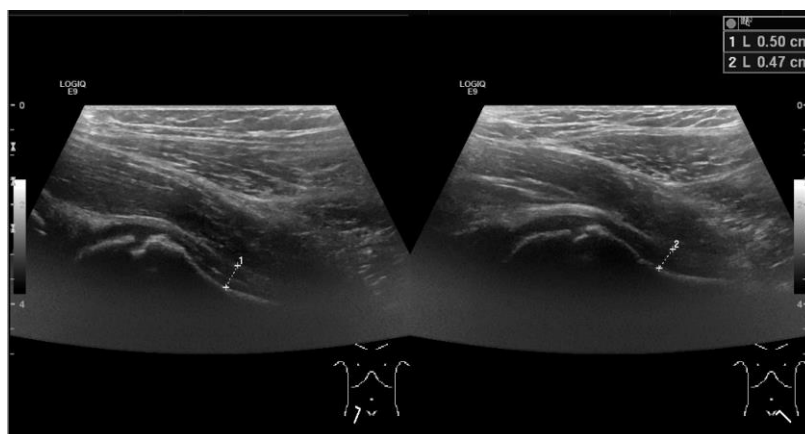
Ultrasonography of the hips which shows no sign of intraarticular abnormalities.
